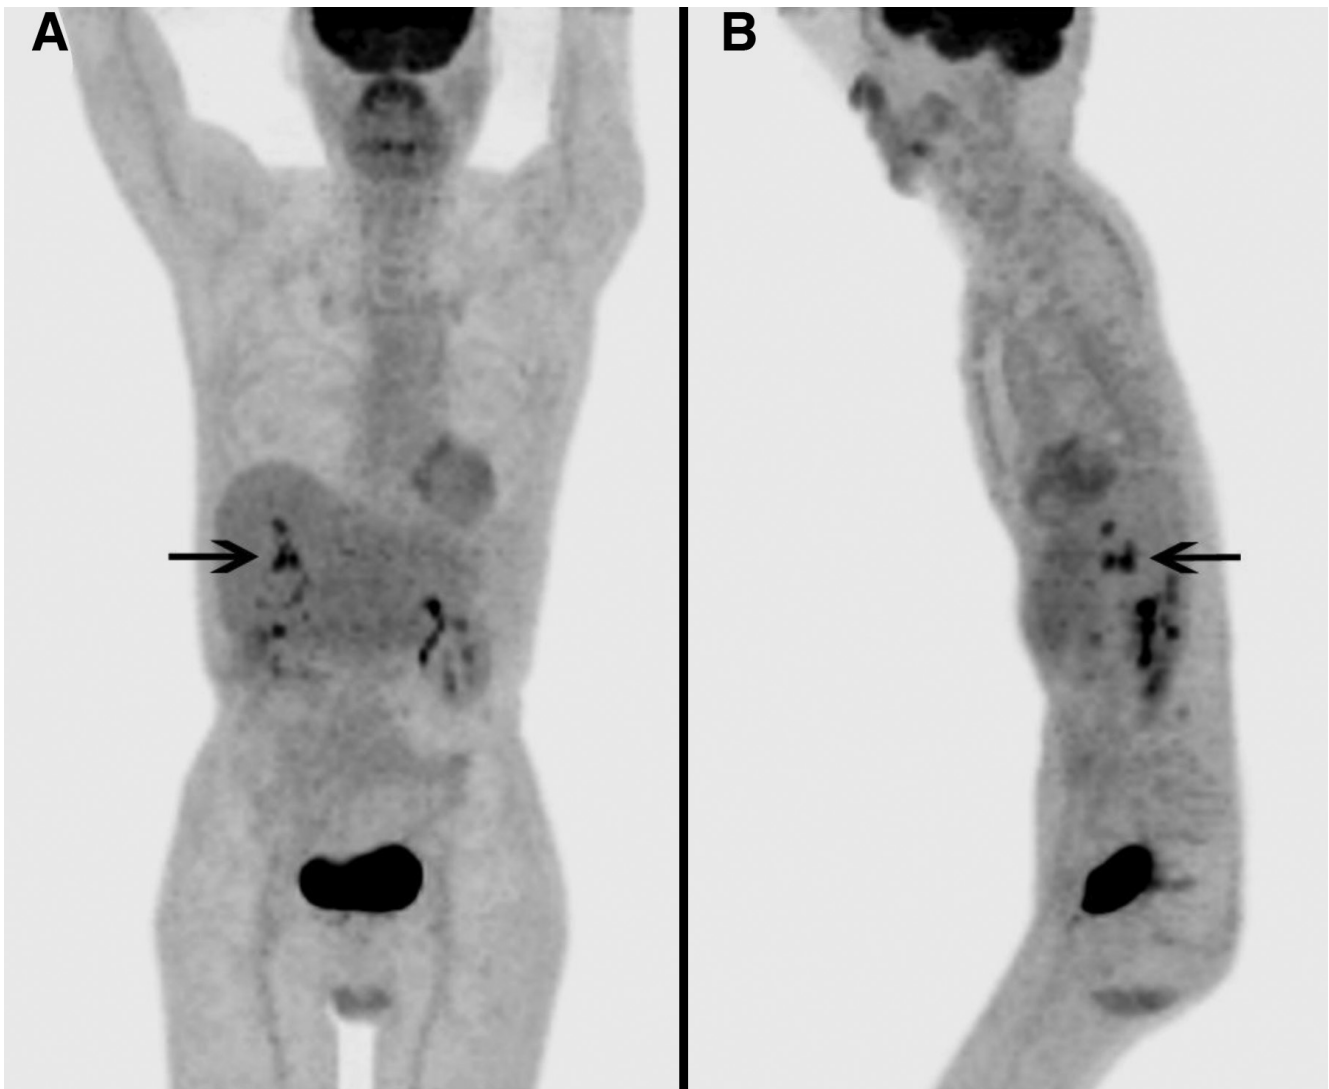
A 65-year-old male had a liver transplant one year prior, for hepatitis B cirrhosis and hepatocellular carcinoma (HCC) with a 3.5 cm lesion in the left lobe and a 4 cm lesion in the right. For several months prior to positron emission tomography/computed tomography (PET/CT), the patient had persistently elevated liver function tests but multiple transjugular biopsies showed no evidence of transplant rejection. Seven endoscopic retrograde cholangiopancreatographies (ERCPs) were performed as the patient developed recurring stenoses and strictures of intrahepatic bile ducts, with failed attempts of cannulation, balloon dilation and stent replacements. The patient tested positive for Epstein-Barr virus and underwent PET/CT to rule out post transplant lymphoproliferative disease (PTLD). Maximum intensity projection images showed multiple foci of intense ^{18}F -FDG uptake in the liver in segments 5, 6, 7 and 8, with maximum standardized uptake value of 9.0, concerning for malignancy.
